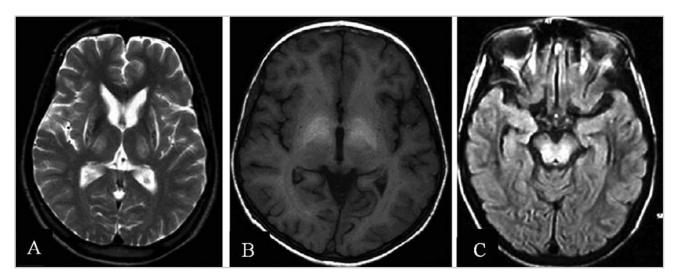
MRI brain A) T2 weighted image, B) T1 weighted image C) FAR image
